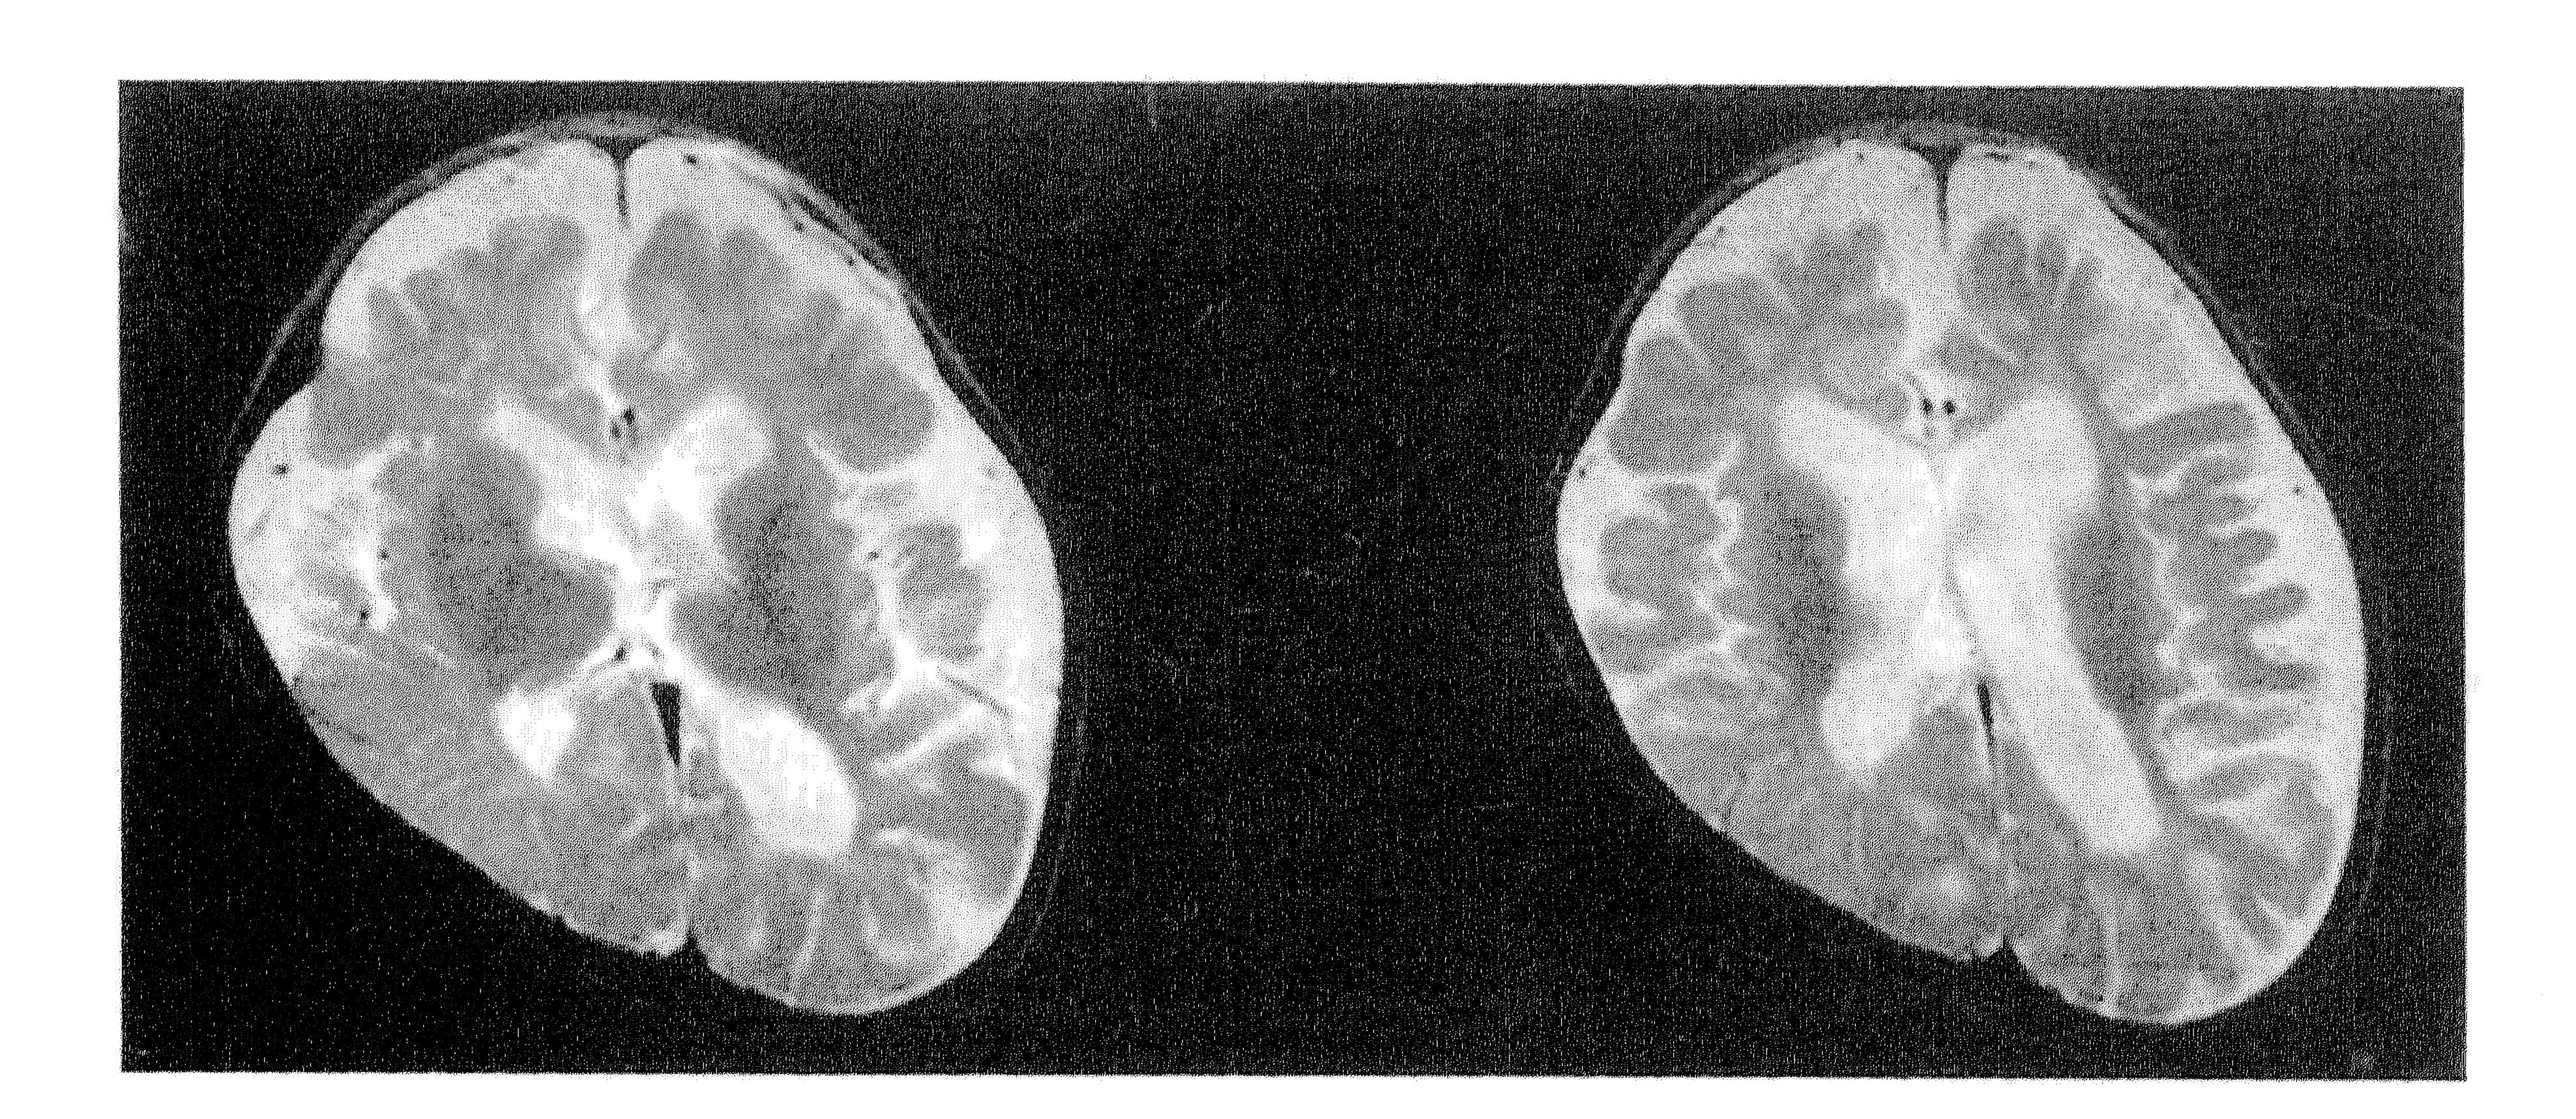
MRI of the patient showing diffuse neuronal degeneration with secondary delay of myelination.
